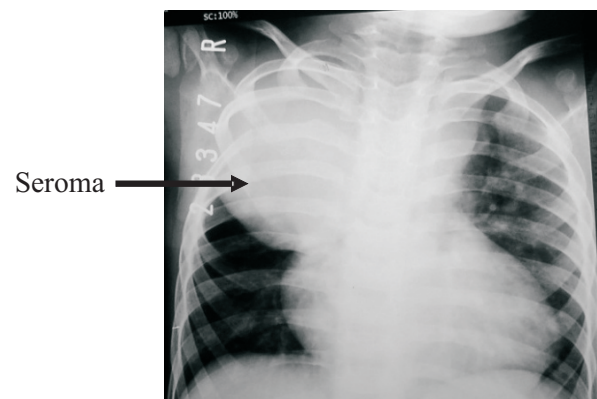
Chest X-ray two years after BT shunt
